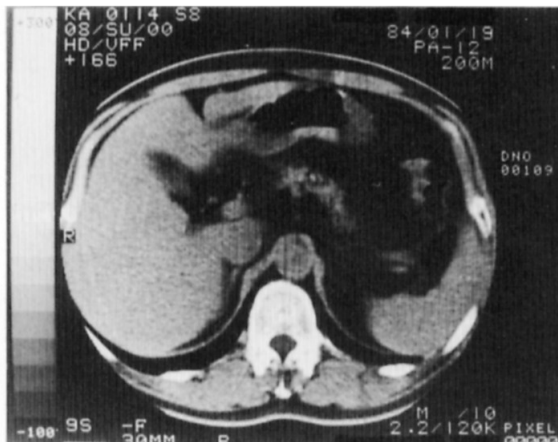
CT scan of pancreas with rough-granular margin and content
